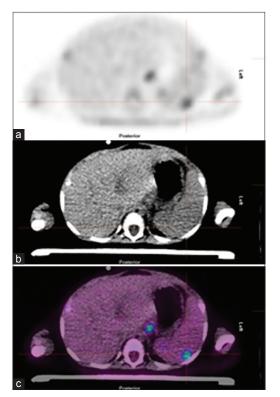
Axial PET(a), low dose CT(b) and fused PET/CT(c) images images showing a hypermetabolic lesion in the spleen (maximum standardized uptake value 2.4) with no definite low dose computed tomography correlate
